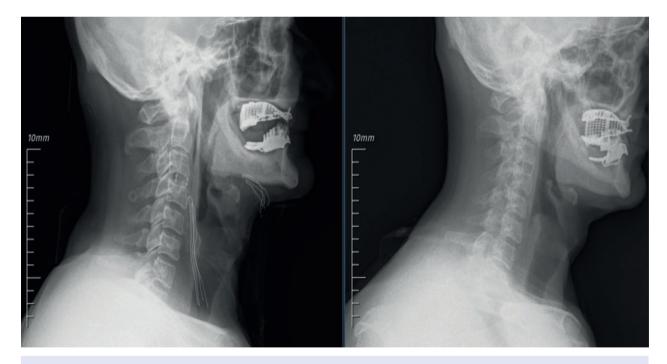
Cervical X-ray images postoperatively (left) and one month later (right) (Normal).
